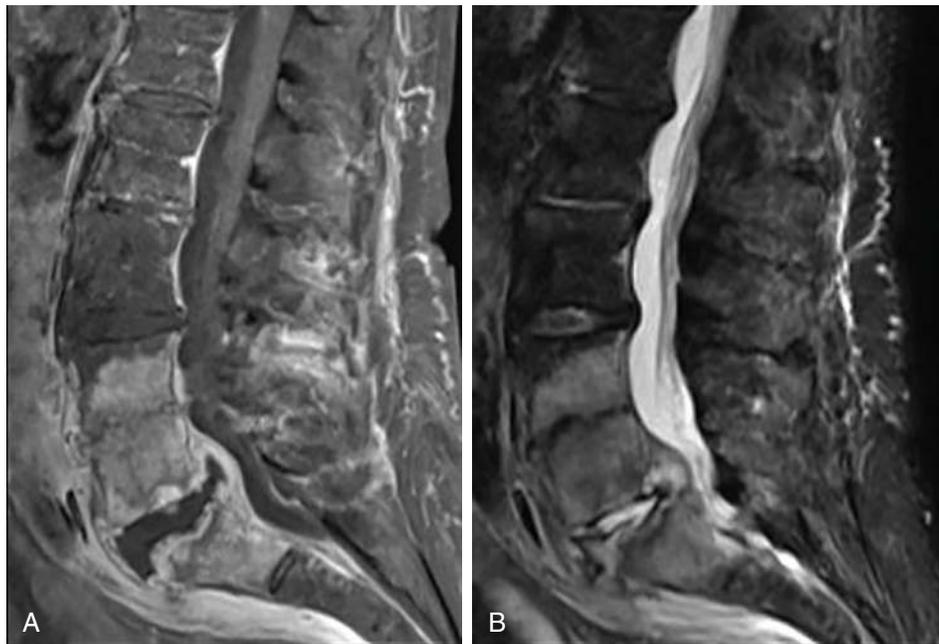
Spondylodiscitis of the lumbar spine. A, T1-weighted MRI of the lumbar spine with contrast shows abnormal contrast enhancement of the L5 and S1 vertebral bodies, representing osteomyelitis. There is a hypointense collection in the L5–S1 intervertebral space, which extends posteriorly into the ventral epidural space, resulting in a peripherally enhancing epidural abscess. B, Short-tau inversion recovery (STIR) MR of the lumbar spine shows abnormal hyperintense fluid signal in the L5–S1 intervertebral disc space, representing infected material within the disc space, and hyperintensity throughout the L5 and S1 vertebral bodies, representing marrow edema.
